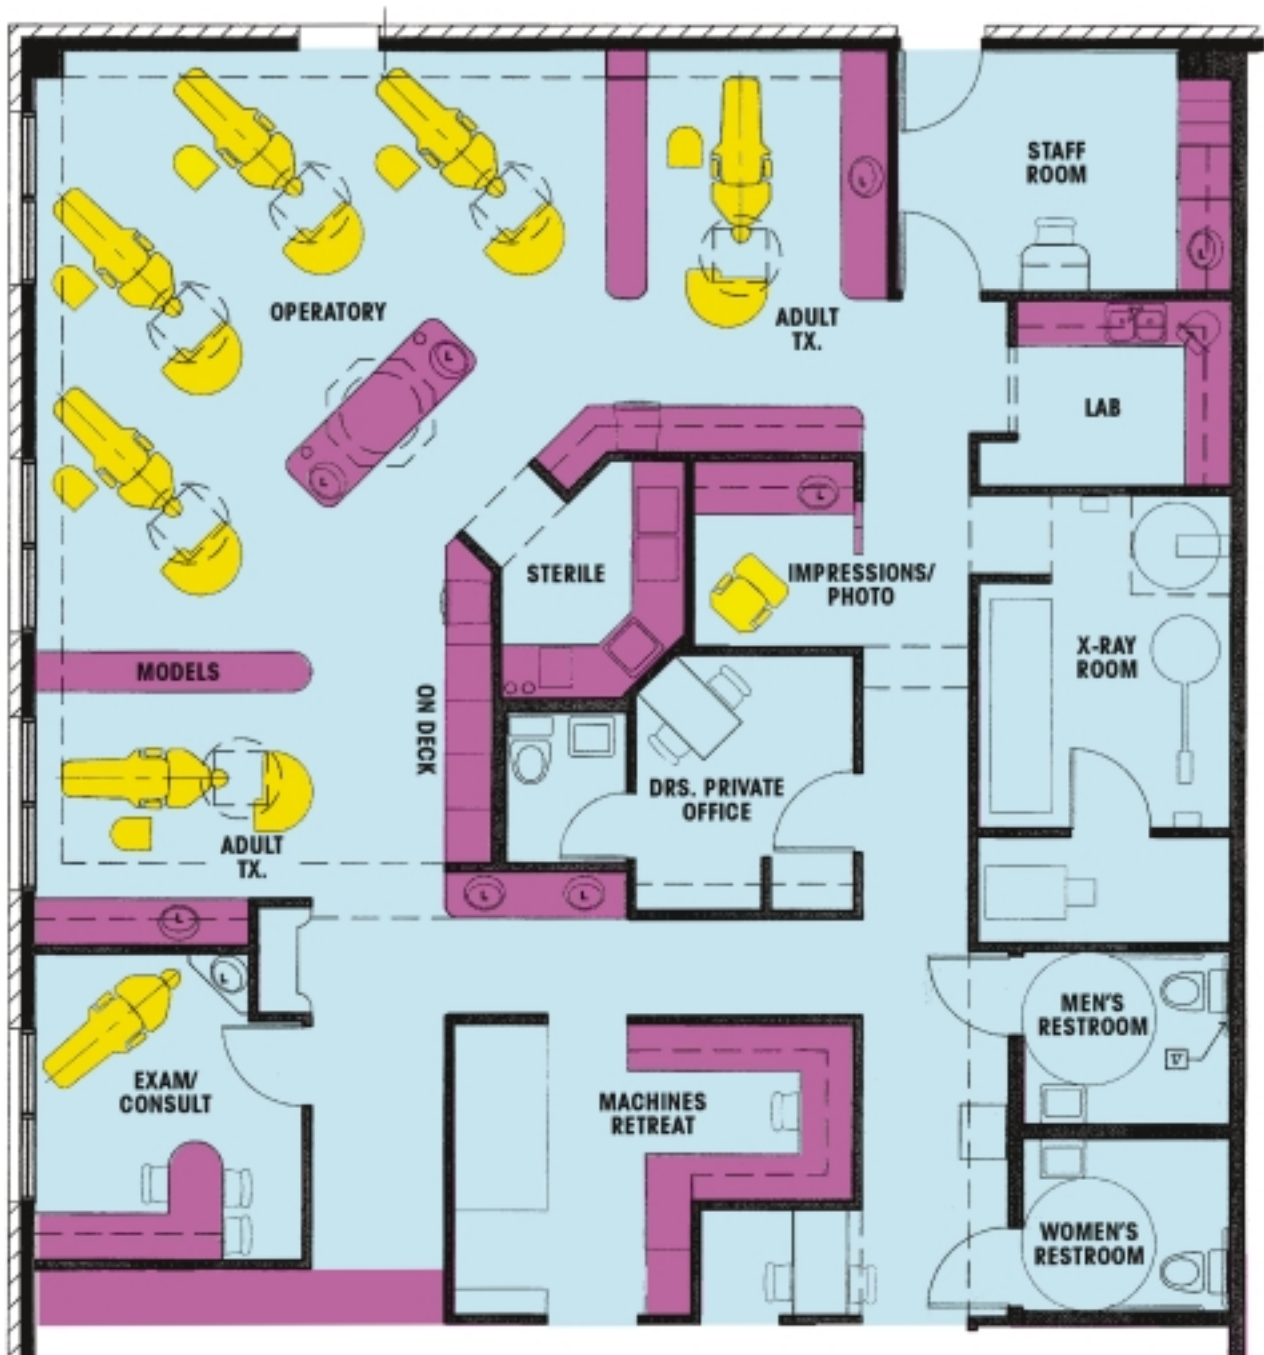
Transitional office design for Dr. Harry Bussa, Katy, TX (2,900 square feet). Three secondary chairs in records room and treatment coordinator's office were added to six operatory chairs. Another secondary chair could be gained by remodeling large x-ray room.
